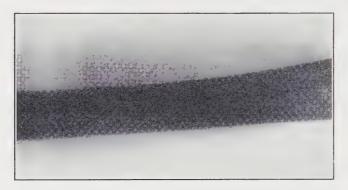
X-ray taken one month after operation
